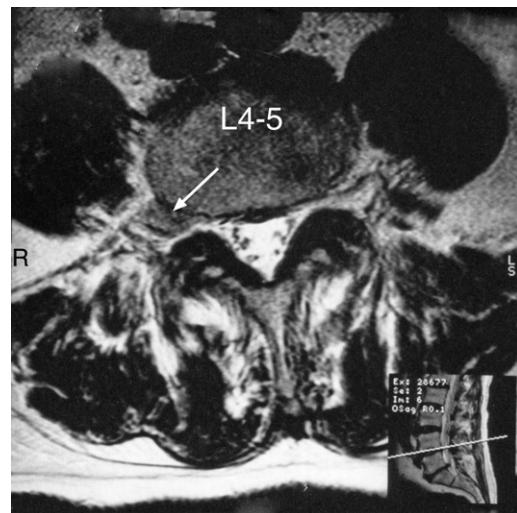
MRI axial T2-weighted image at the L4–5 level showing a right foraminal and far lateral disc extrusion (arrow) producing compression of the exiting right L4 nerve. Moderate zygapophysial facet joint degenerative change is present bilaterally.
